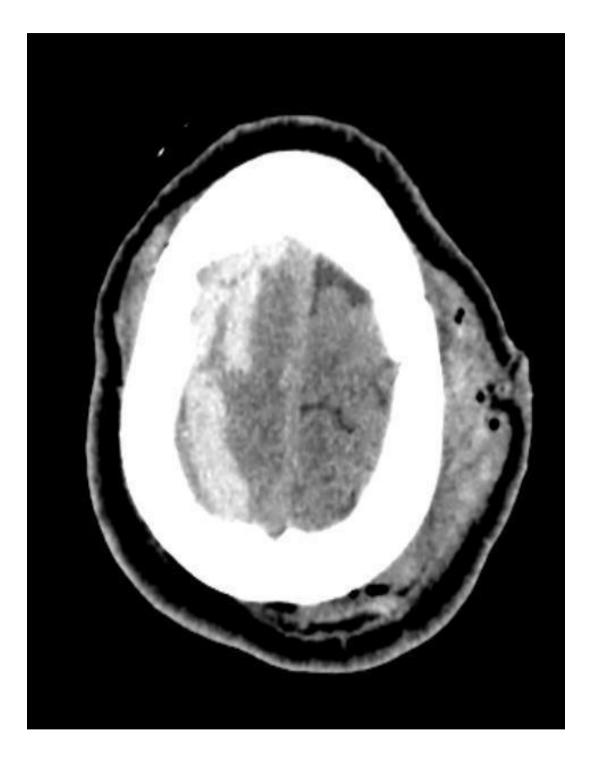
Axial CT scan demonstrates Soft tissue swelling with air foci in left parietal region and only soft tissue swelling in right frontal region.
